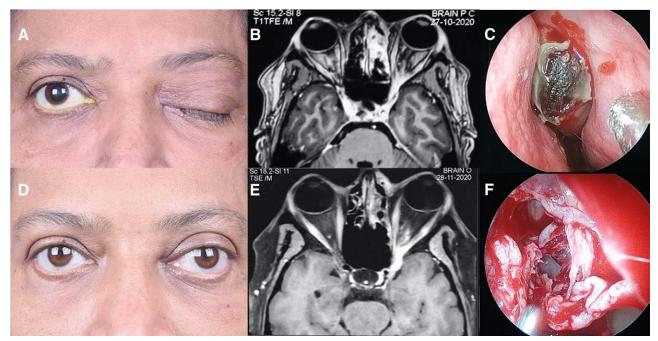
Pre and post-operative clinical, MR and endoscopic images of a patient with left rhino-orbital-cerebral mucormycosis. A, A 53-year-old diabetic lady presented with complaints of severe peri-orbital pain, ptosis, and vision loss. B, MRI orbit was suggestive of left orbital cellulitis with cavernous sinus thrombosis and left ethmoidal sinusitis. C, diagnostic endoscopy revealed a black eschar in the left nasal cavity. D, She was treated with sinus debridement and iv amphotericin-B following which there was partial resolution of ptosis. E, Post debridement MRI demonstrating a decrease in the sinus load. F, Post endoscopic sinus debridement.
